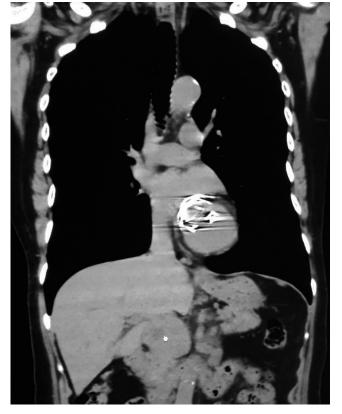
CT scan where the retroperitoneal mass or adenomegaly located behind the head of the pancreas can be observed.
